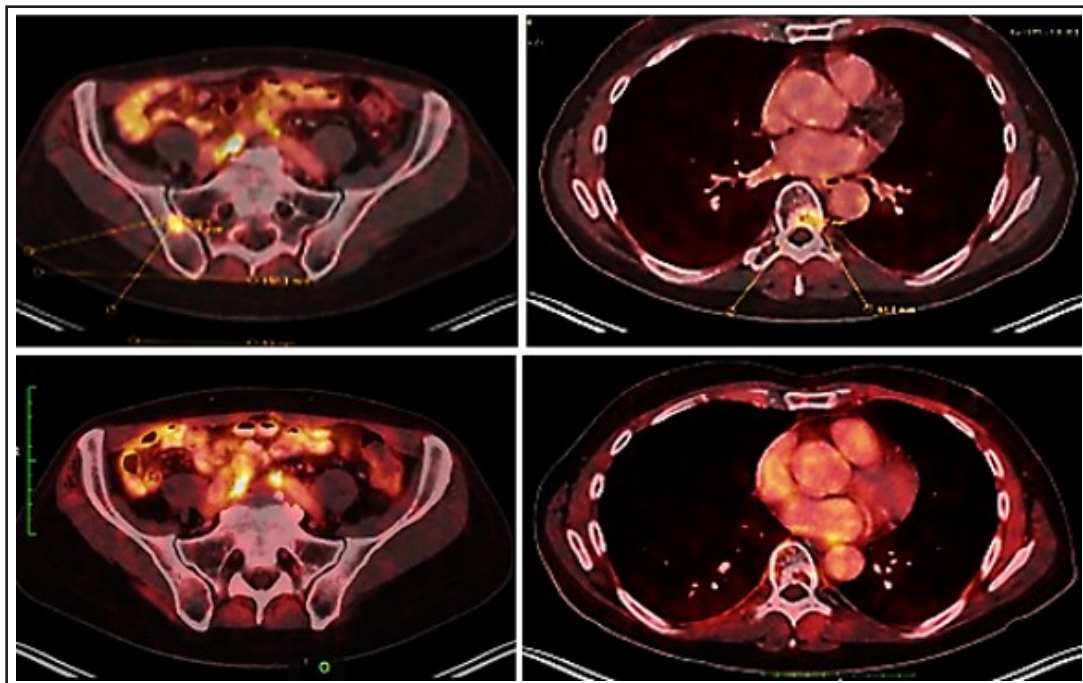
PSMA PET-CT showing osseous metastases in the ilium and the 8th thoracic vertebra before TMI treatment (above) and regression of the osseous metastases six months after the start of TMI treatment (below).
